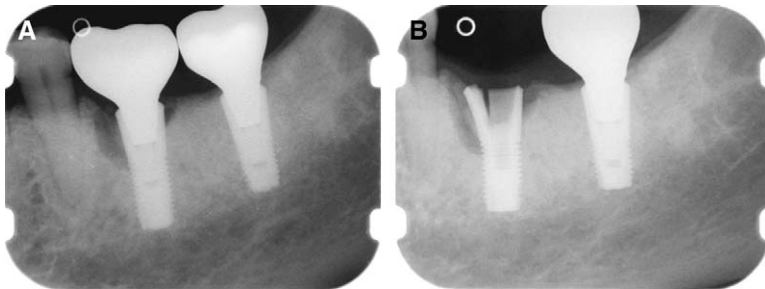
Periapical radiograph of endosseous implant indicating peri-implant bone loss (A) and following removal of the prosthesis and abutment (B). The case was diagnosed with a fractured implant (technical failure) most likely due to short implant length and occlusal load.
